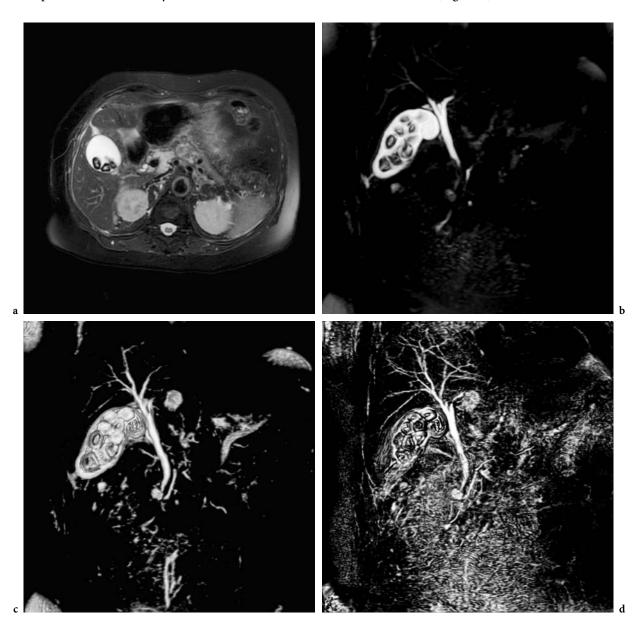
Gallstones. Axial T2-weighted FSE image (a) shows multiple stones in the gallbladder. Coronal thin MIP 3D heavily T2-weighted MR cholangiogram (b) depicts gallbladder lithiasis and shows a normal caliber of hepatic ducts and the common bile duct. MR VR images better demonstrate these findings; in particular, VR using a small threshold (c) permits the visualization of the subtle details, such as the calculi, while VR with a large threshold (d) permits an easier visualization of the entire biliary system
